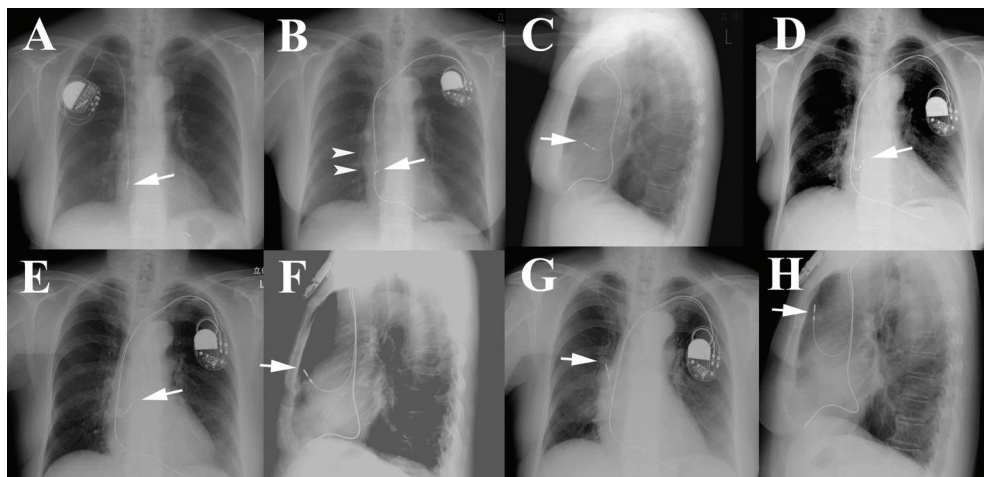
Chest X-rays. Compared to the image before the replacement of the pacemaker (A), the image taken 1 week after the replacement (B) showed only a focal protrusion from the right side of cardiac silhouette (arrowheads) and the lateral image (C) did not show any abnormalities. The image taken 2 years later had no serial change (D), however the image from 3 years and 9 months later (a lateral view; F) clearly showed atrial lead protrusion, while the lead changed to tip-tilted on the frontal view (E). One year later, both of frontal (G) and lateral views (H) demonstrated the progression of atrial lead protrusion. The arrows indicate the distal tip of the atrial lead. (From Sadamatsu K, et al. (2009). Progressive atrial lead perforation developed 5 years after pacemaker replacement. *J Cardiol*, 53,150-153)
